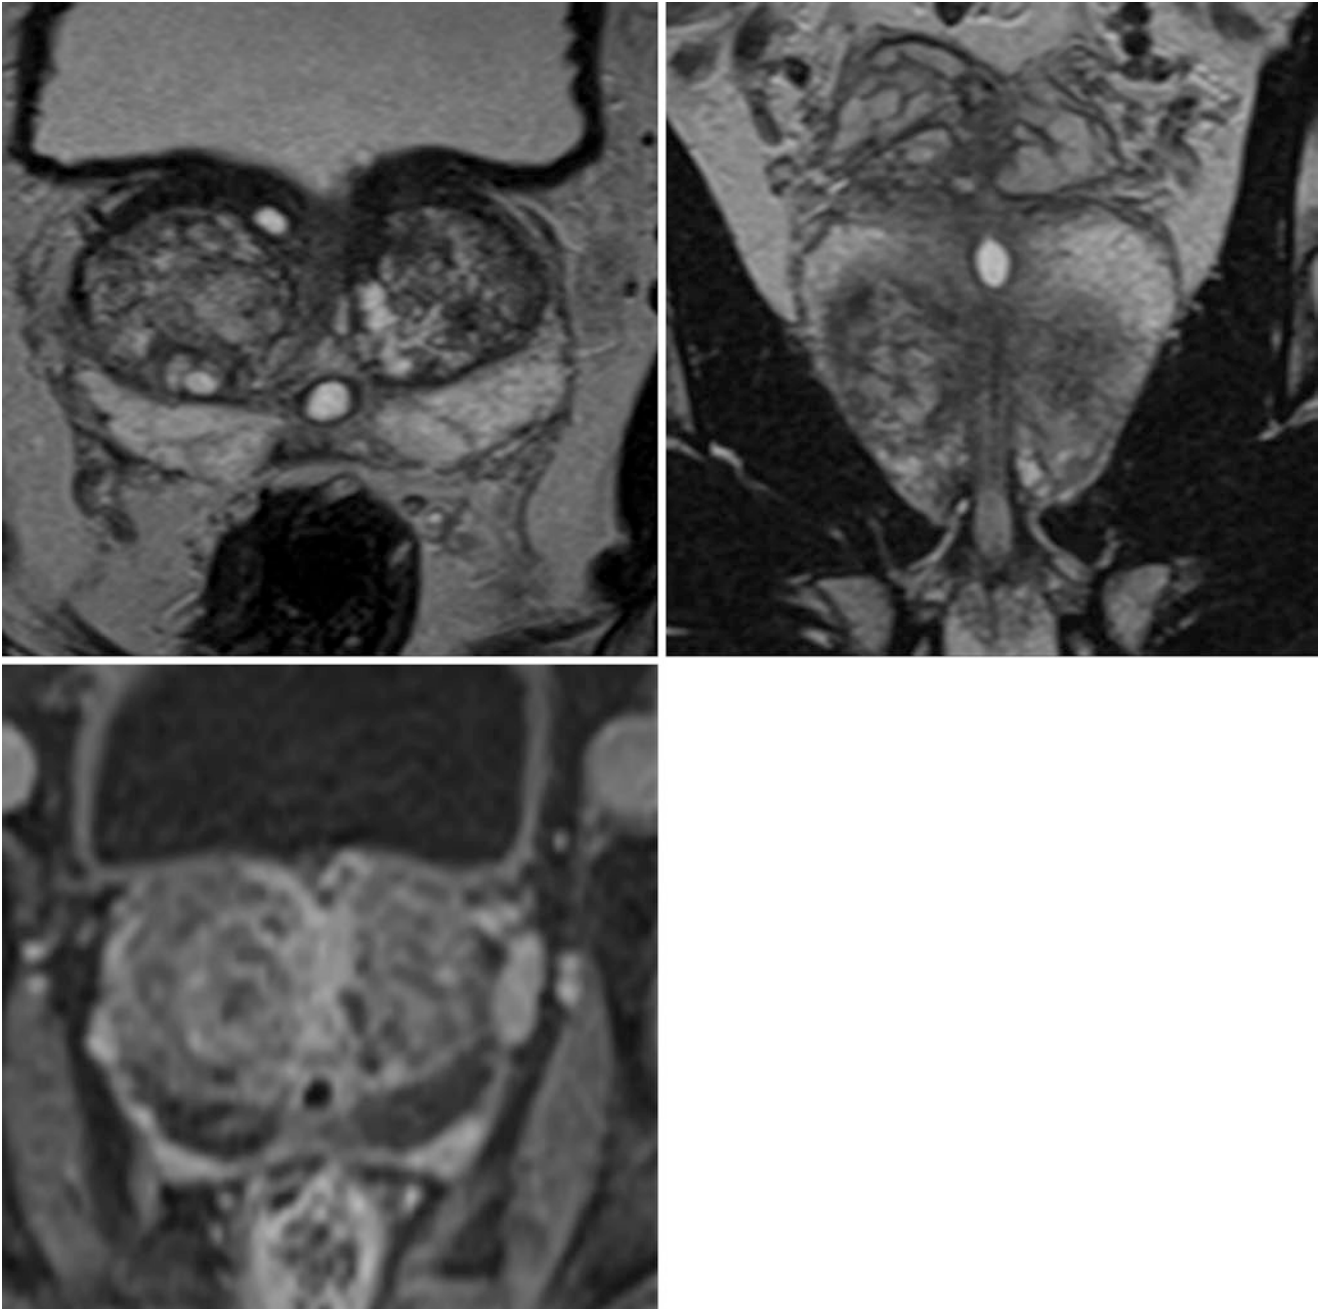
Prostatic utricle cyst in a 30-year-old man. Axial (a), coronal (b) T2-weighted MR images and axial (c) contrast-enhanced fat-suppressed T1-weight MR image show a midline high-signal-intensity prostatic utricle cyst
